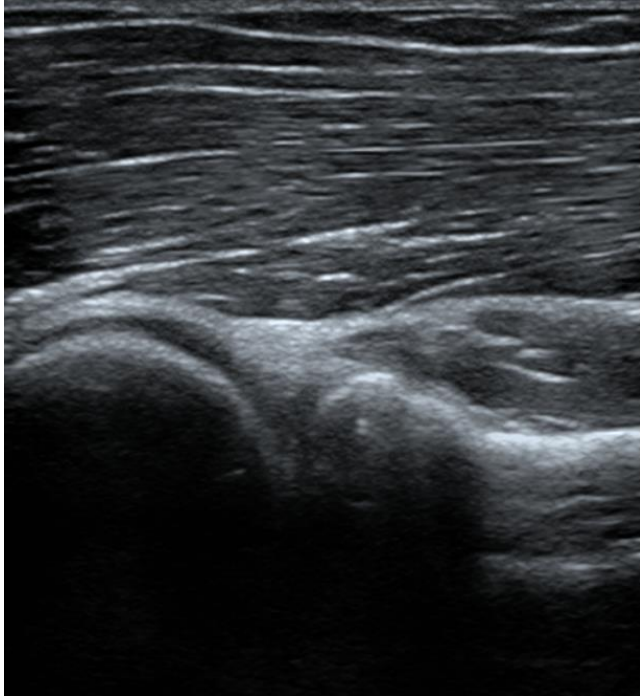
Ultrasonography of right elbow. Ultrasound of right elbow demonstrating hyperechoic and triangularly shaped morphological feature consistent with a posterolateral radiohumeral plica.
